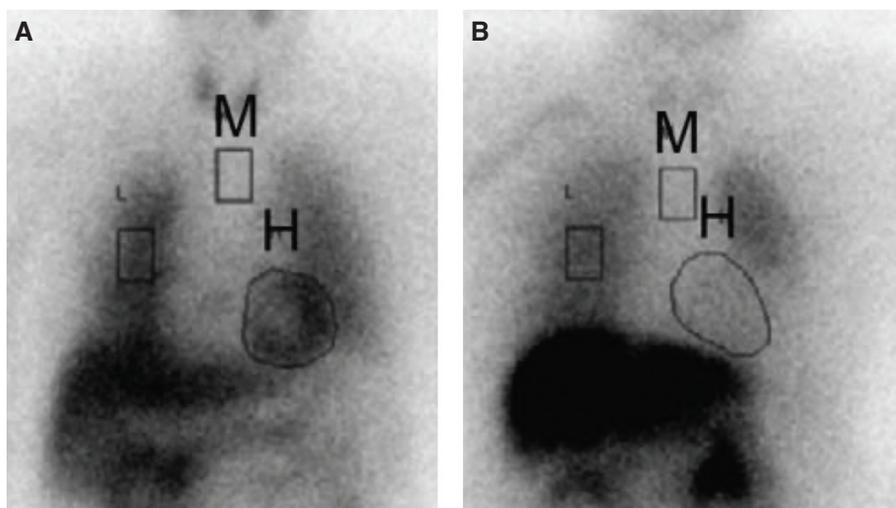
123I-MIBG scintigraphy. Early anterior planar images of myocardial 123I-MIBG scintigraphy in control patient (A) and patient with idiopathic Parkinson's disease (IPD) (B). Regions of interest enclosing 123I-MIBG uptake were placed in the mediastinum and heart (labeled with M and H, respectively). Cardiac uptake is less in patients with IPD. Source: J Nucl Med. 2006;47(7):1099–101. Published with permission.
